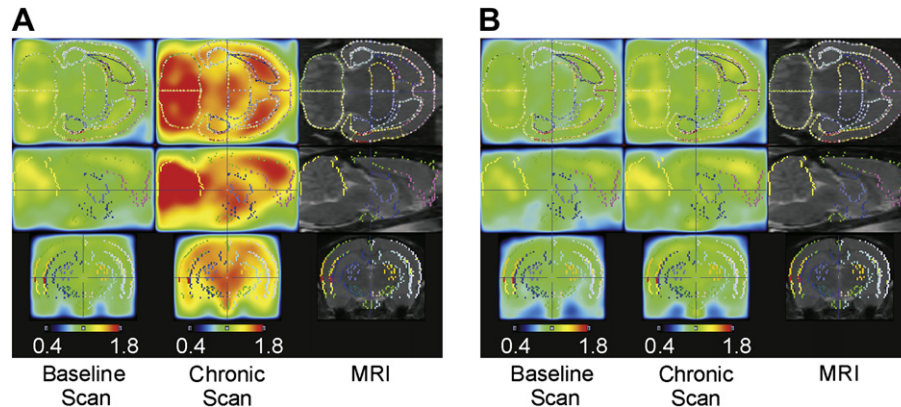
Average cross-sectional SUV images of baseline and chronic (day 14) scans after VPA (A) or LEV (B) treatment coregistered to MRI, with volume-of-interest-overlay.
